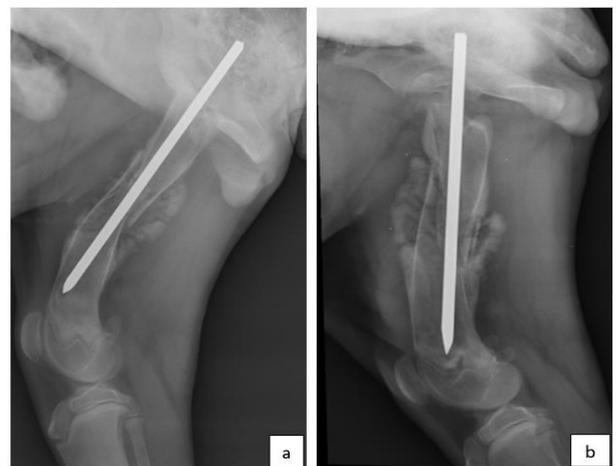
a and b. 15th day medio-lateral postoperative radiograph showing periosteal reaction at the fracture site in right and left femur bone respectively
